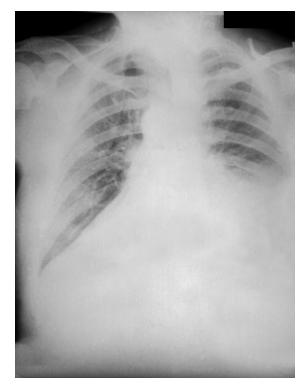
Typical chest X-ray from a case patient with inhalation anthrax. This aspect shows a widened mediastinum (lower separation seen on film between lobes of the lungs) and pleural effusion (opaque area below right). *Courtesy of the Centers for Disease Control and Prevention*.
